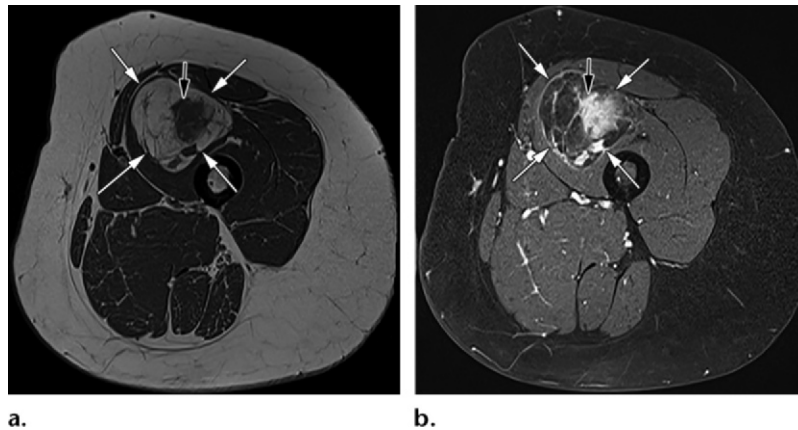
DDLPS in a 58-year-old woman with a painful left anterior thigh mass. (a) Axial T1-weighted image shows a primarily fat-containing mass (white arrows) within the quadriceps musculature with multiple irregular septa and a large, irregular, hypointense nodule centrally (black arrow). (b) Axial postcontrast fat-saturated T1-weighted image of the mass (white arrows) shows intense enhancement of the central nodule (black arrow) and internal septa.
